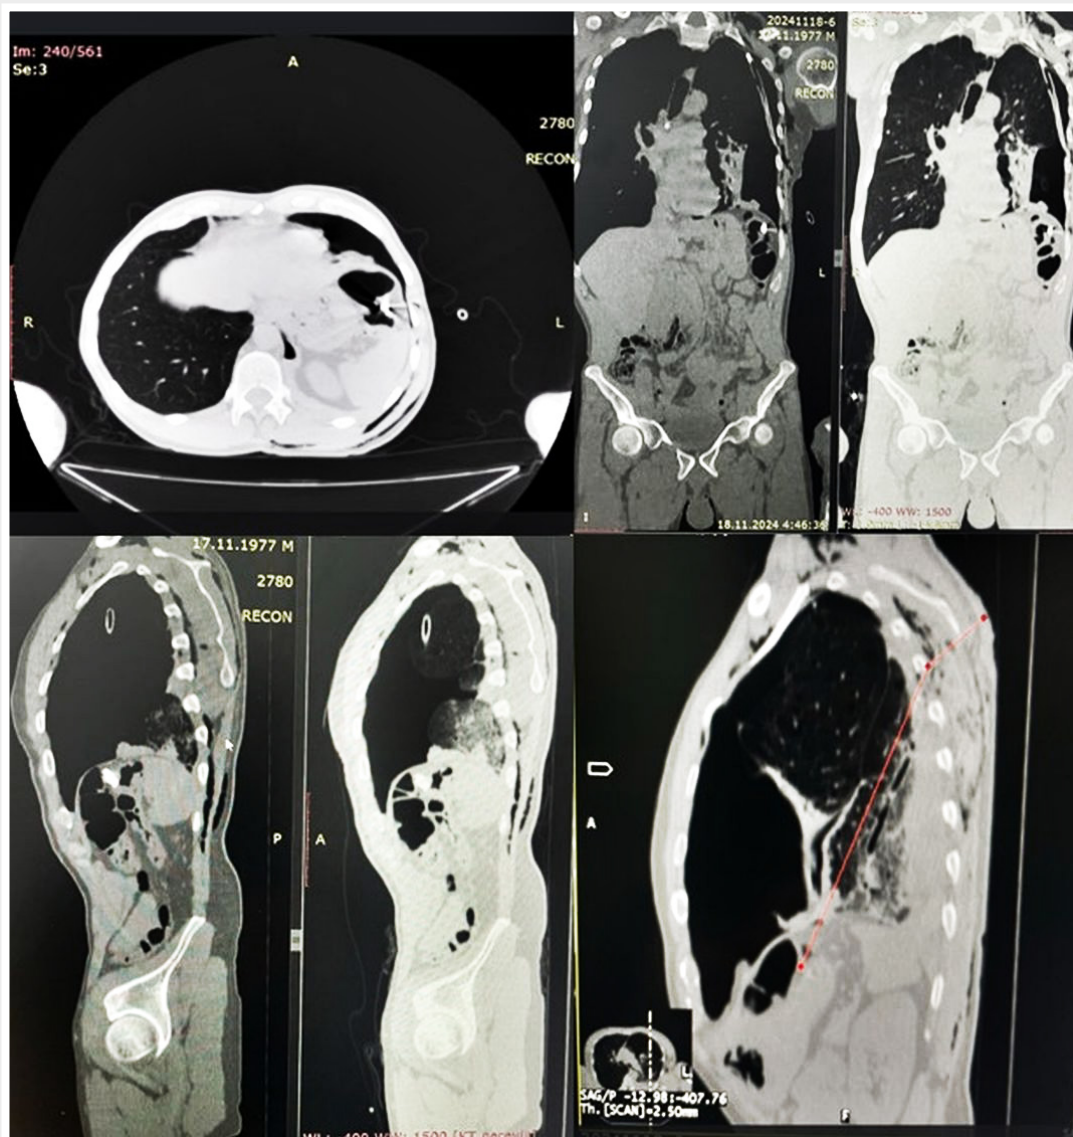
CT-scans. Penetrating gunshot wound with internal and external damage to the lower lobe of the left lung, perforation of the diaphragm on the left, and transverse colon perforation with a retained metal fragment.
